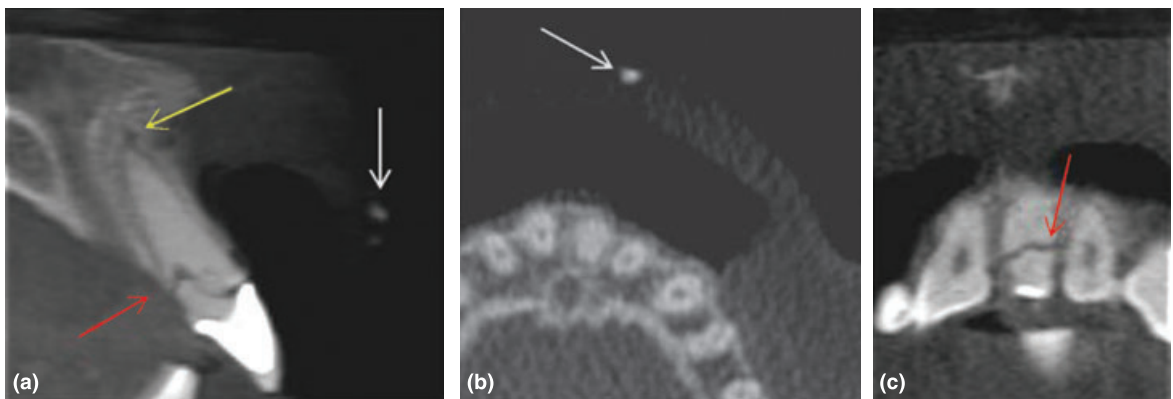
A single cone beam computed tomography scan used in the management of a root fracture and luxation injury. The (a) sagittal and (b) axial views reveal the presence and exact location of the fractured portion of the crown fragment (white arrow) in the upper lip. The scan also reveals an oblique fracture of tooth 21 (red arrow) and widened labial apical-third periodontal space as a result of a lateral luxation injury (yellow arrow).
